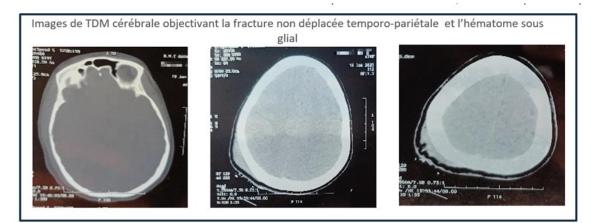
CT images showing the non-displaced temporo-parietal fracture and subgaleal hematoma
